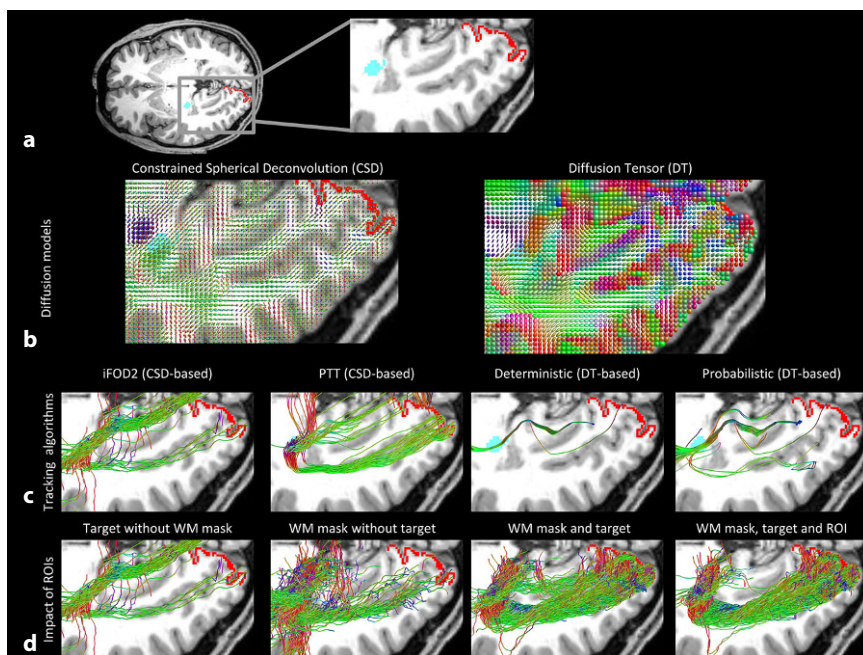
▲ Exemplary diffusion models, tractography algorithms, and tracking strategies. a The axial slice of the T1-weighted image with highlighted LGN (cyan) and V1 (red). b Two exemplary models fit to the data: constrained spherical deconvolution (CSD; left) and diffusion tensor (DT; right). c Sample streamlines connecting LGN and V1 generated using different tracking algorithms (from left to right): second-order Integration over Fiber Orientation Distributions (iFOD2) based on CSD model, Parallel Transport Tractography (PTT) based on CSD model, deterministic algorithm based on DT, and probabilistic algorithm based on DT. d Impact of incorporating regions of interest (ROIs) in the iFOD2-based tractography. From left to right: streamlines connecting LGN to V1, but not limited to white matter (WM); streamlines generated in LGN and limited to white matter but not requested to reach V1; streamlines connecting LGN and V1 and limited to white matter; streamlines connecting LGN and V1, limited to white matter and requested to pass through user-defined ROI (enforcing anatomical plausibility of streamlines). (Image courtesy of Otto von Guericke University Magdeburg)
